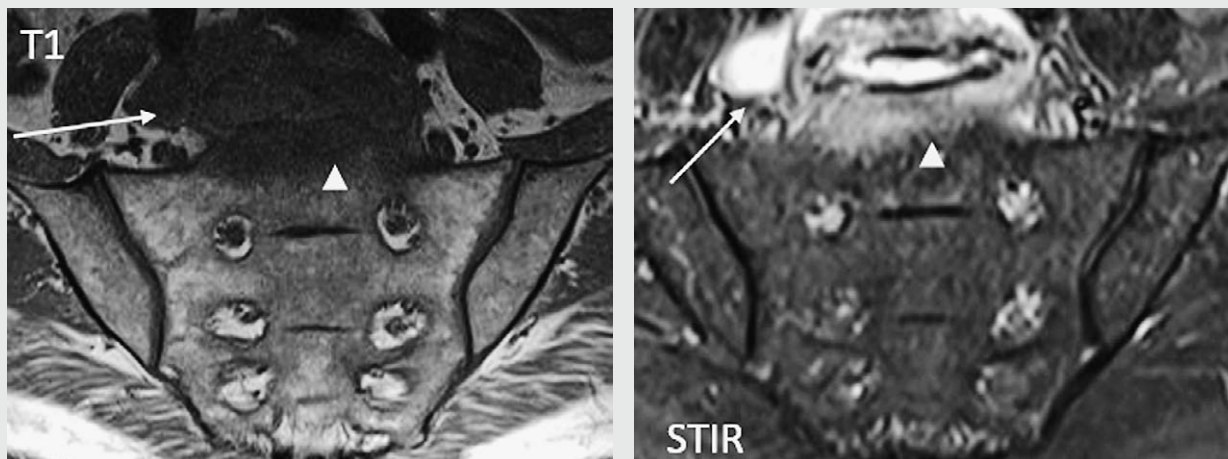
MRI of coronal cross-section of the lumbosacral L5-S1 spine in STIR (short TI inversion recovery) and T1 images which show inflammatory changes. Arrowhead: bone oedema – high signal in STIR and low signal in T1; long arrows: epidural abscess – low signal in T1, high signal in STIR.
